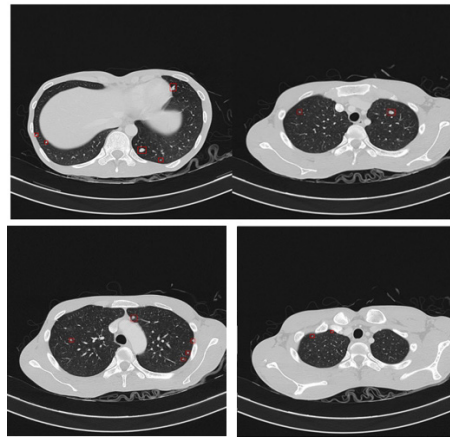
Example of the labelled CT-Scanned nodule images
